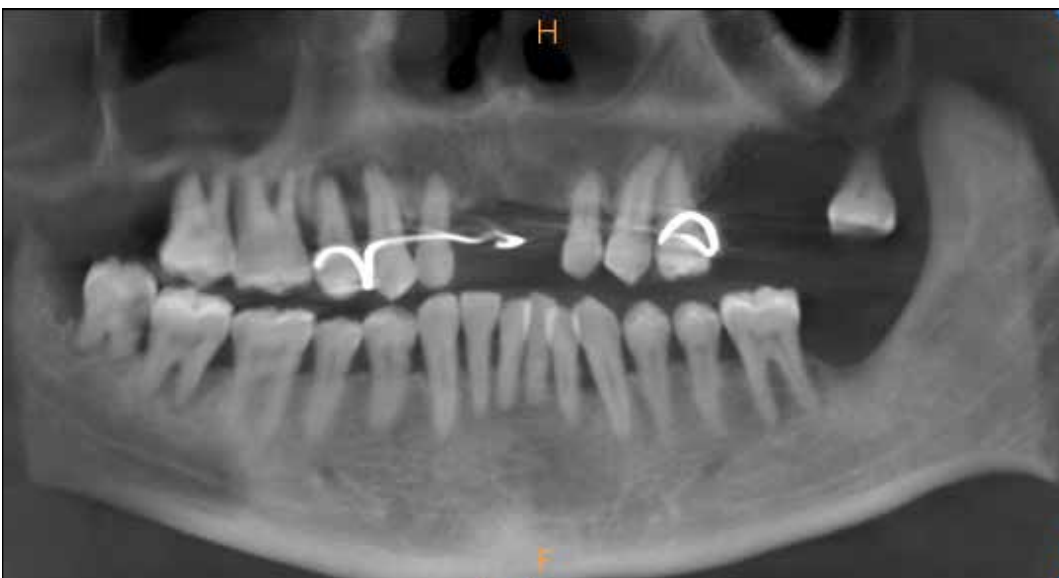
Panoramic radiograph showing missing upper right premolar bud (November 2013)
